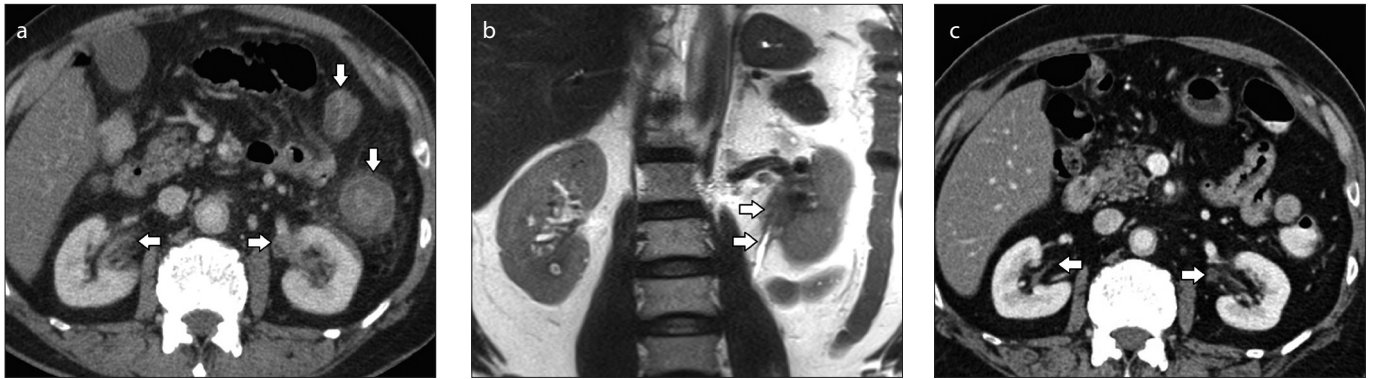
a–c. Axial CT (a) showing asymmetric thickening of the ureteric wall, more prominent on the left than on the right (*horizontal arrows*) and colonic edema (*down arrows*). Coronal T2-weighted image (b) through the left renal pelvis in the same patient shows mass-like thickening of the ureter wall, which later decreased on the left and resolved on the right with corticosteroid treatment (c, *horizontal arrows*).
